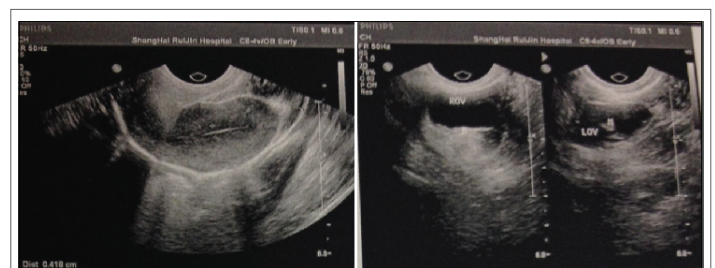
The result of ultrasound
